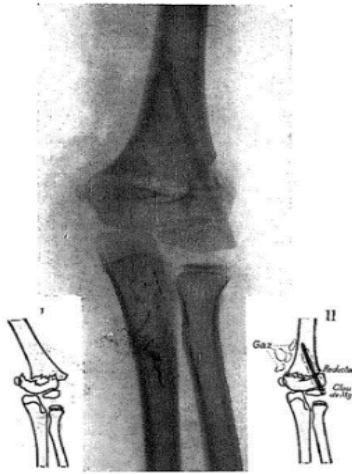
Verbrugge displayed a supracondylar postoperative X-ray. A Dow magnesium nail was used to cure a child's fracture who was 7 years old [152]. It is possible to witness the early stages of subcutaneous gas production [158].
